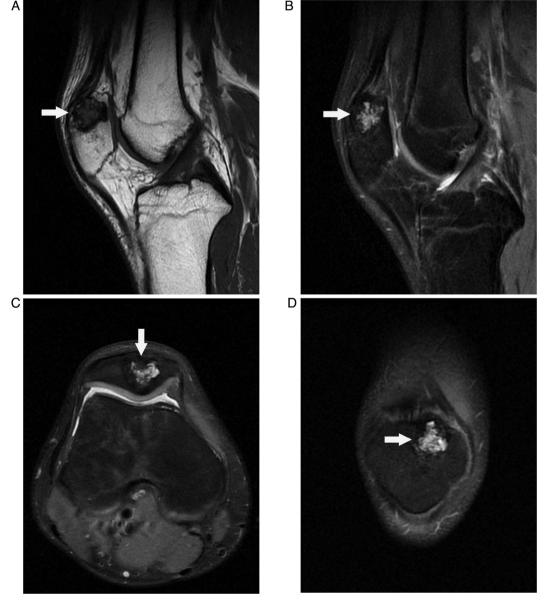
Magnetic resonance imaging showing a low-intensity signal mass on the T1-weighted image and a high-intensity signal mass on the T2-weighted image with a well-defined lesion of the patella. (A) Sagittal plane of the T1-weighted image. (B) Sagittal plane of the T2-weighted image. (C) Axial plane of the T2-weighted image. (D) Coronal plane of the T2-weighted image.
